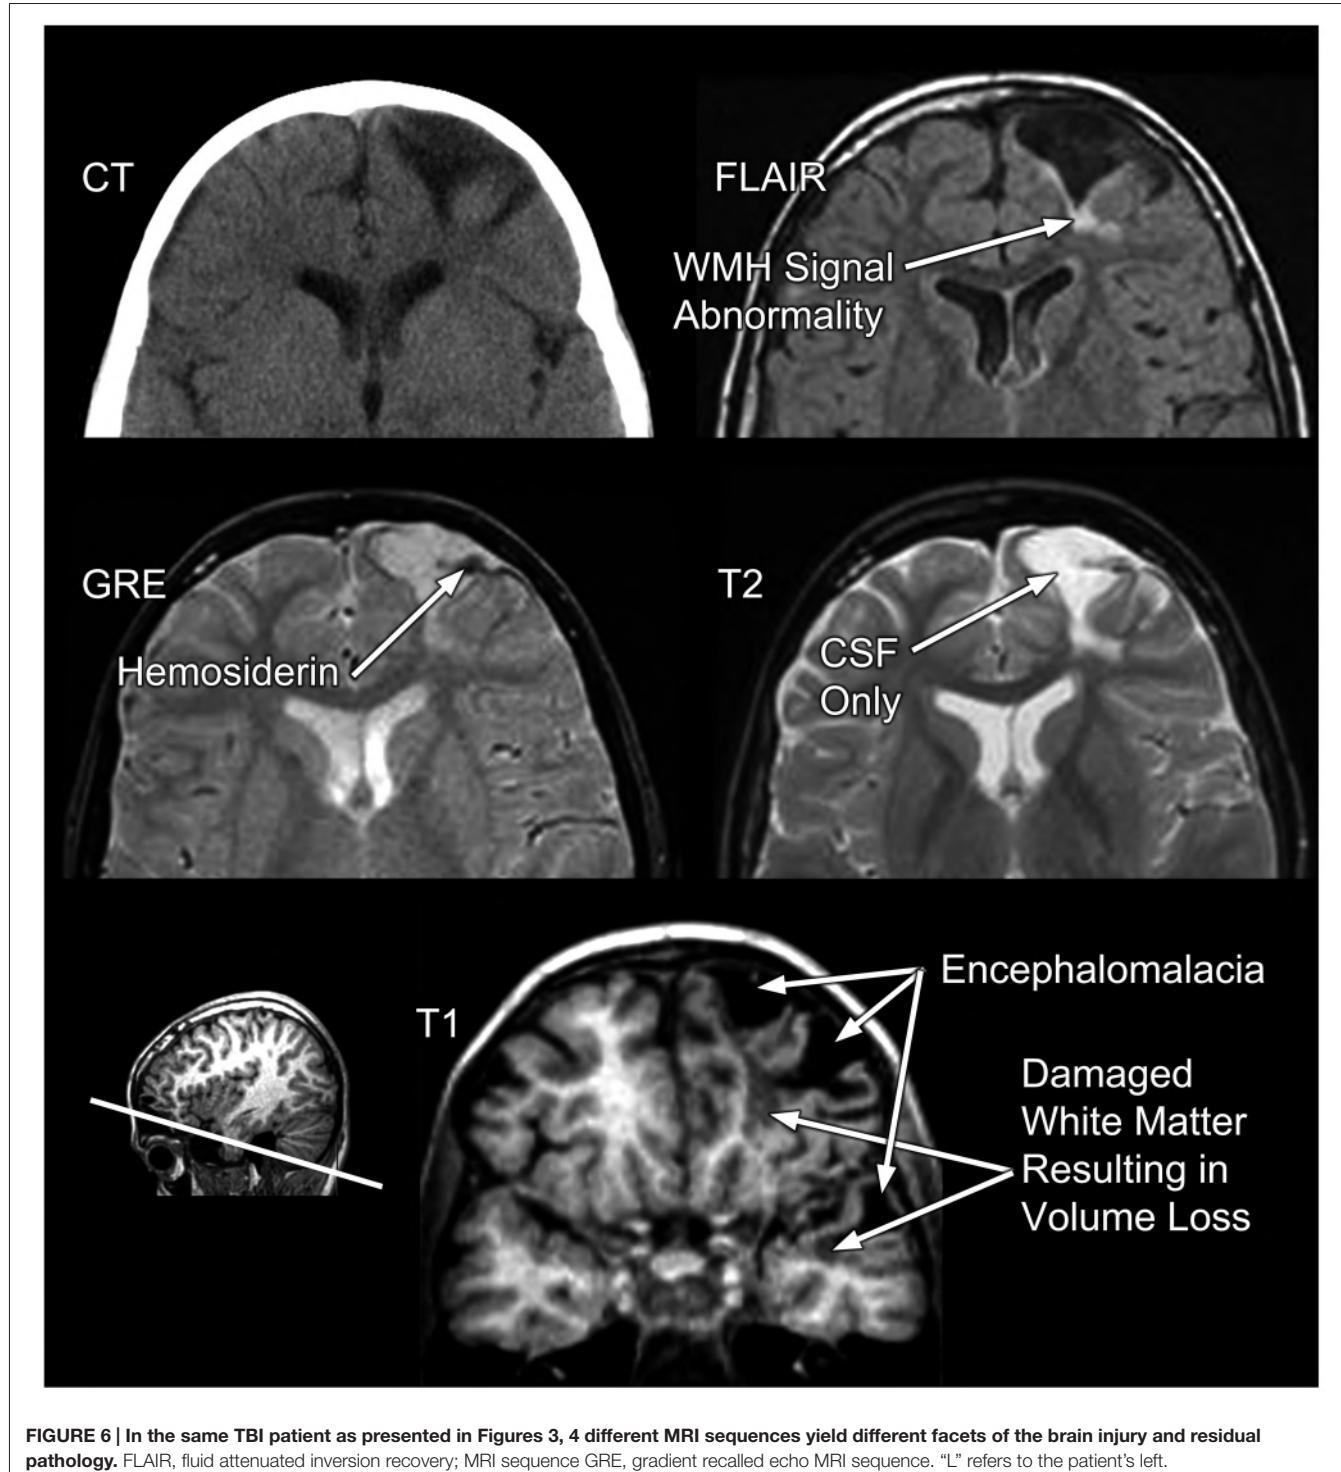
In the same TBI patient as presented in Figures 3, 4 different MRI sequences yield different facets of the brain injury and residual pathology. FLAIR, fluid attenuated inversion recovery; MRI sequence GRE, gradient recalled echo MRI sequence. “L” refers to the patient’s left.
